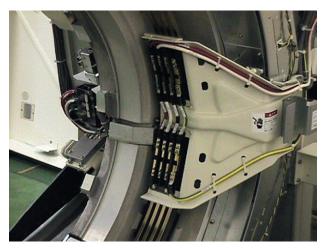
Slip rings and brushes electrically connect the components on the rotating gantry with the rest of the multislice helical computed tomography imaging system. (Courtesy Terry Williams, Toshiba Medical Systems.)
